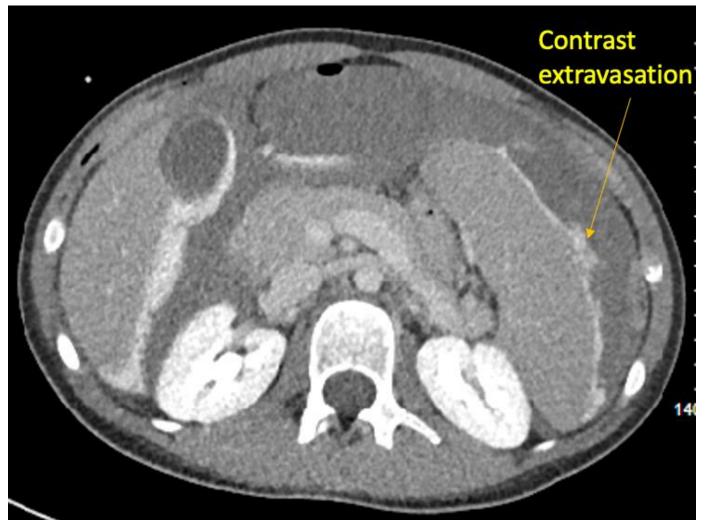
CT mesenteric angiogram showing splenic rupture with intraperitoneal contrast extravasation
